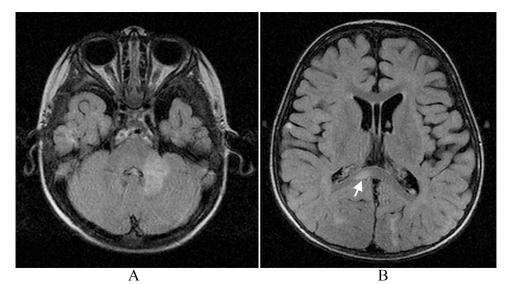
Axial brain MRI images, in fluid attenuated inversion recovery (FLAIR) sequence showing; (A) Abnormal high signal intensity is noted at the left cerebellar peduncle, with extension to the left cerebellar hemisphere. (B) Abnormal high signal intensity of the splenium is seen (arrow). Notice multiple foci of abnormal signal intensities at the right temporal cortex and bilateral occipital regions.
